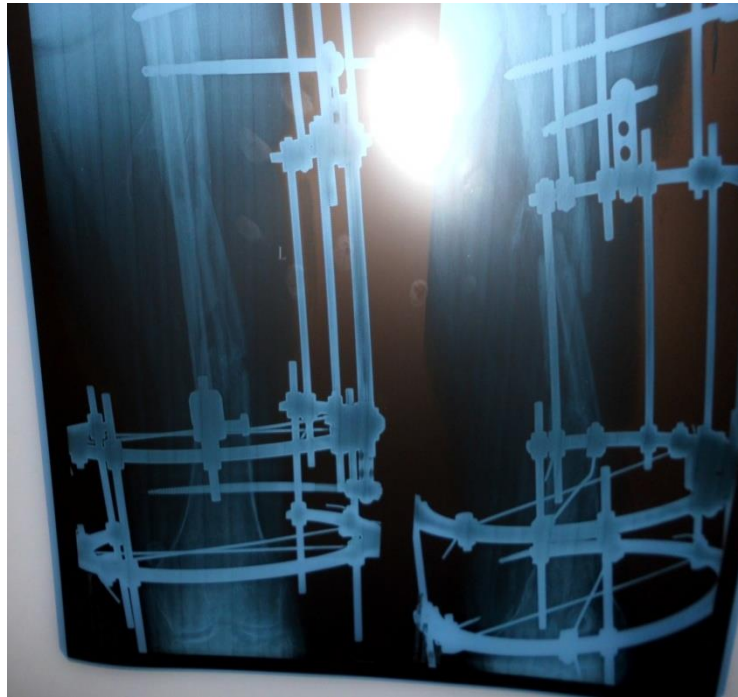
21.07.2015y. Patient was born in 1983. Radiograph of the left femur, after surgery, anteroposterior and lateral views.
